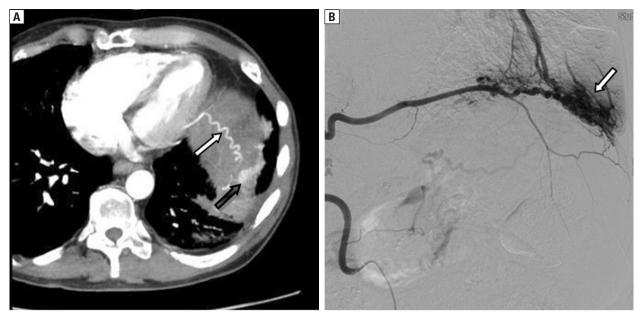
Contrast-enhanced computed tomography images: A. Maximum intension projection (MIP) — the white arrow shows a wide left branch of phrenic artery; the black arrow shows abnormal contrast enhancement in the basal segments of the left lung; B. Angiography (white arrow) confirmed an abnormal vascular anastomosis between the left inferior phrenic artery and pulmonary arteries and veins
